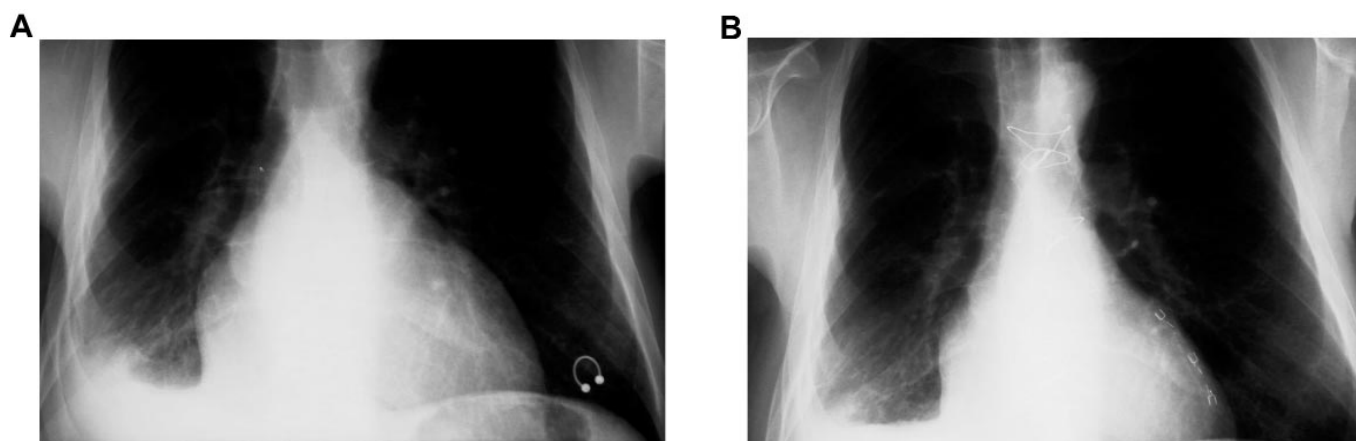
Myosplint implantation alone in a patient with dilative cardiomyopathy at the Department of Cardiac Surgery, Heart Center Leipzig, Germany. Radiographs at baseline (A) and 6 months postoperatively (B). Improved lung-to-heart ratio accompanied with an improvement in the ejection fraction and a reduction in the left ventricular end-diastolic volume (14% to 37% and 334 mL to 145 mL, respectively). Radiographs and data provided by courtesy of Prof. F. Mohr, Heart Center Leipzig, Germany.
